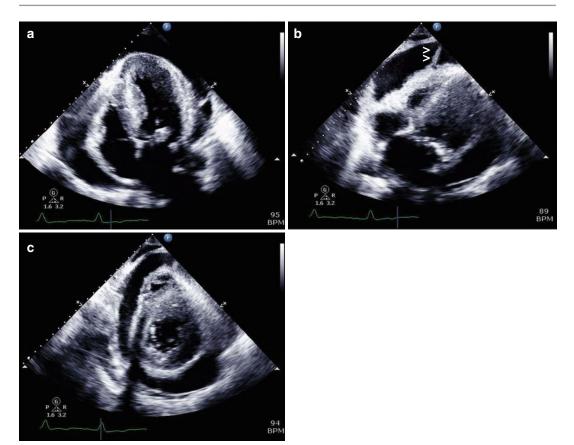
(a) Apical four chamber echocardiographic view in a 37 year old man with pericarditis revealing a large circumferential pericardial effusion. (b) Subcostal echocardiographic view in the same patient as in (a) with pericarditis
